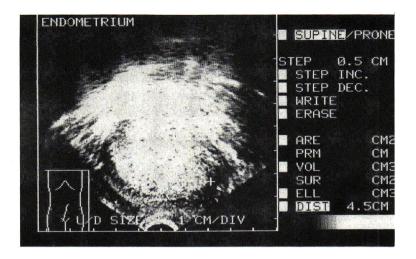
Endovaginal sonography showing choriocarcinoma nodule anterior uterine wall.
